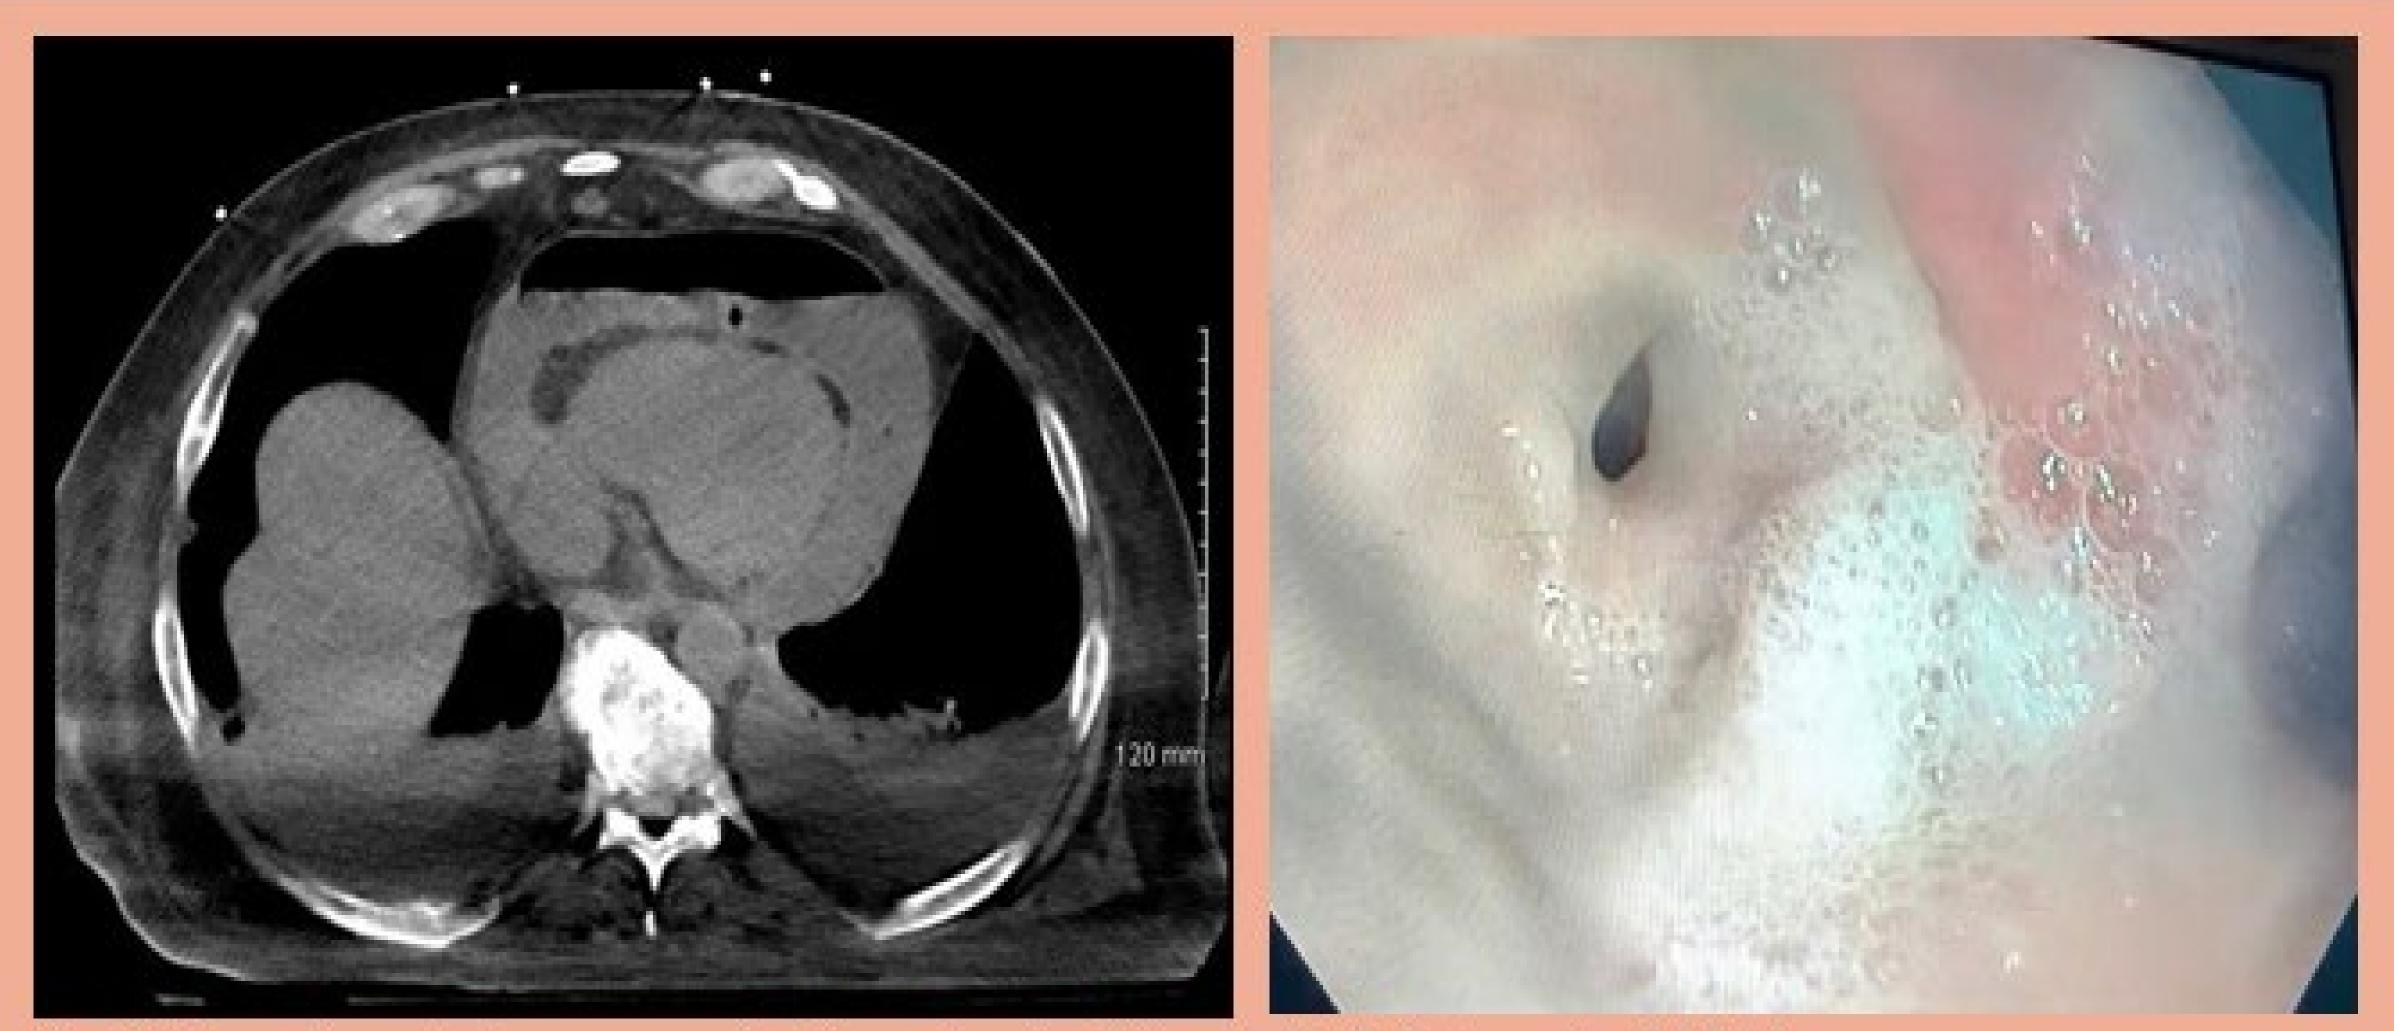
CT scan demonstrating pneumopericardium, and pericardial effusion.
